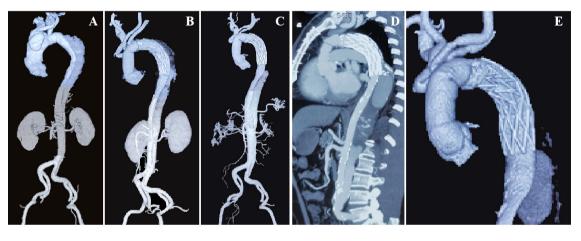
Computed tomography angiography images. (A) Before operation, (B) after operation, (C) one year of follow-up, and (D) and (E) eight years of follow-up.
